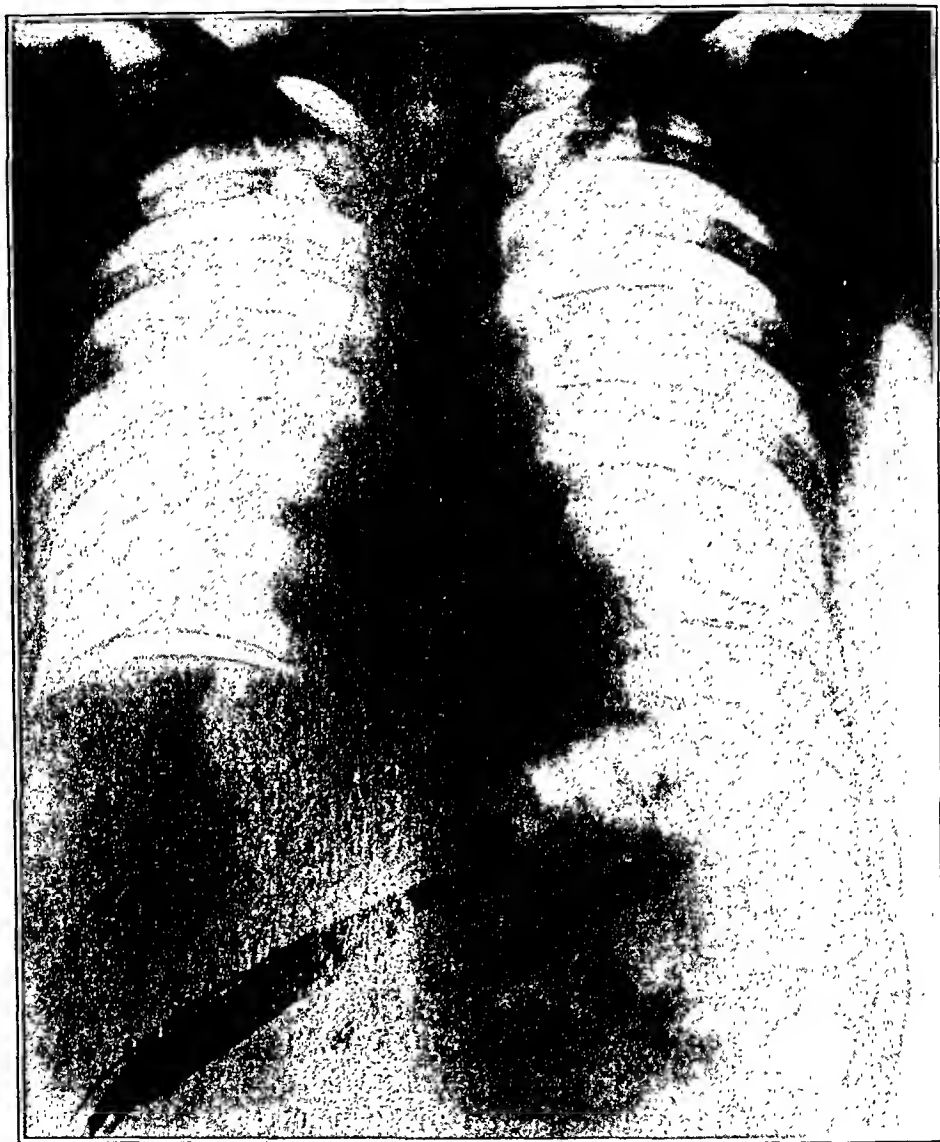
(case 15).—Roentgenogram taken five days after perforation. There is free air beneath both domes of the diaphragm and considerable gas in the splenic flexure. No operation.
